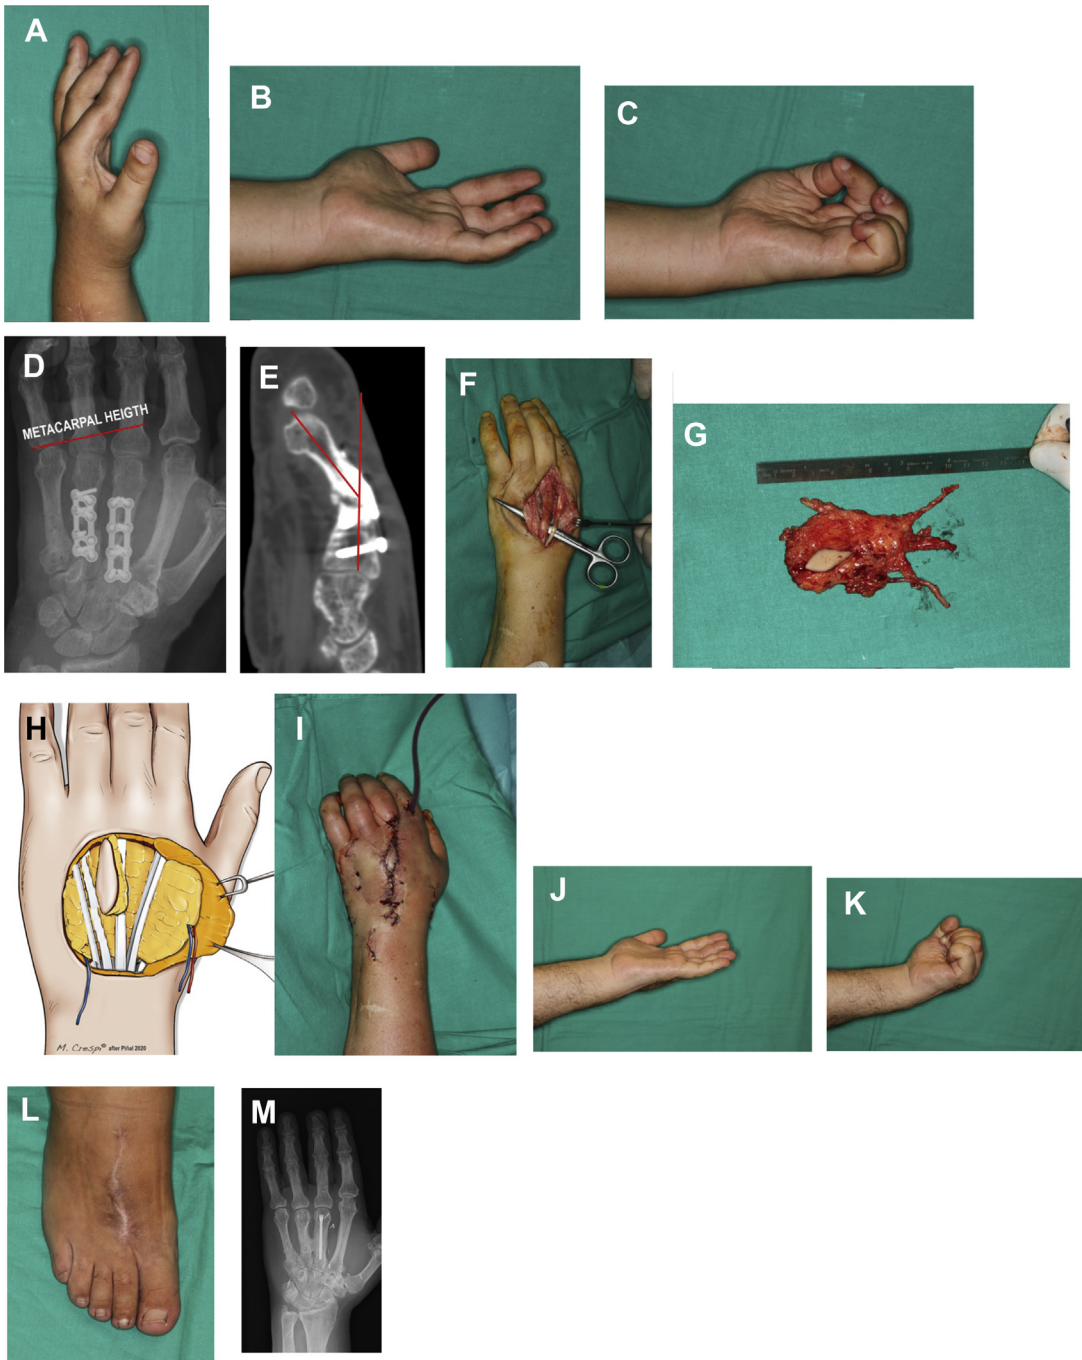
Function at the time of “discharge” during the first consultation. (A-C) Maximum extension and flexion. Note that the MCP joints are stiff in extension. (D) Severe metacarpal shortening, with non-union and malalignment of the 3rd metacarpal (E). (D) Using the original dorsal incision the extensor tendons were released and capsulotomies were carried out in 2-4th MCP joints. (F) Dorsalis pedis fasciosubcutaneous flap, and setting in the bed (H-I). (J-M) Function, donor site and x-ray at 6 months.
